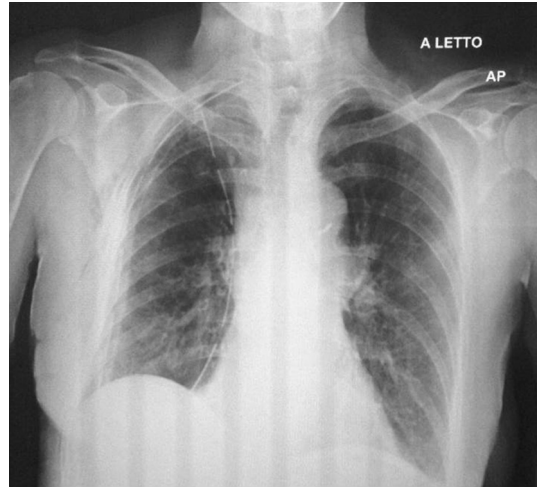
Day 1 postoperative chest radiograph after right upper sleeve lobectomy: 2 chest drains (one anterior, another posterior) have been placed at the end of the intervention. The lung is correctly re-expanded.
